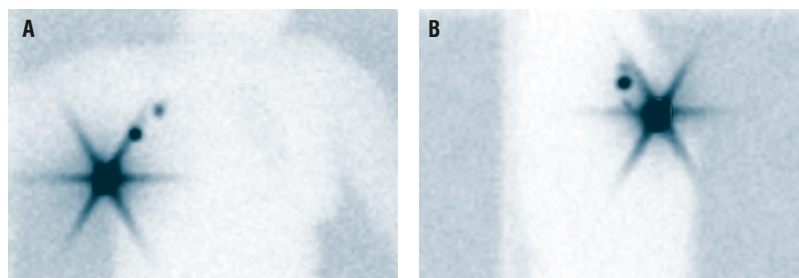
Technetium-99m-nanocolloid scintigraphy. (A) Anterior view (B) Right lateral view.
